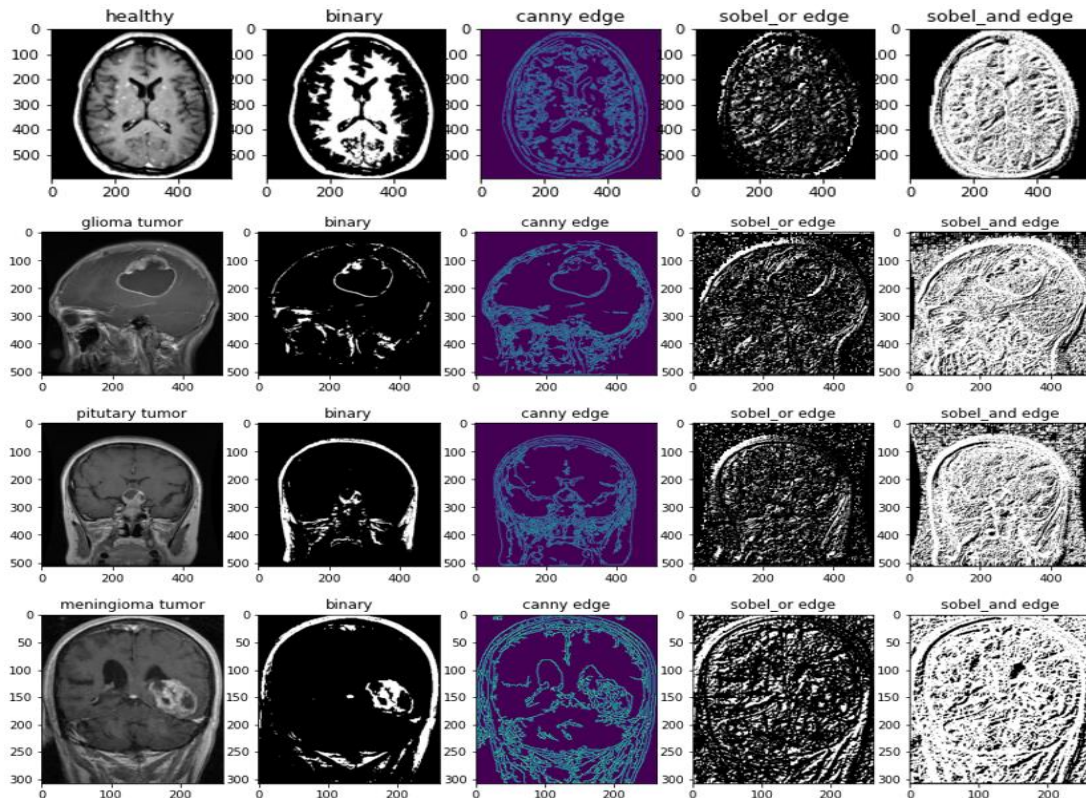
Binarized image, Canny edge detection and Sobel edge detection on brain MRI images
